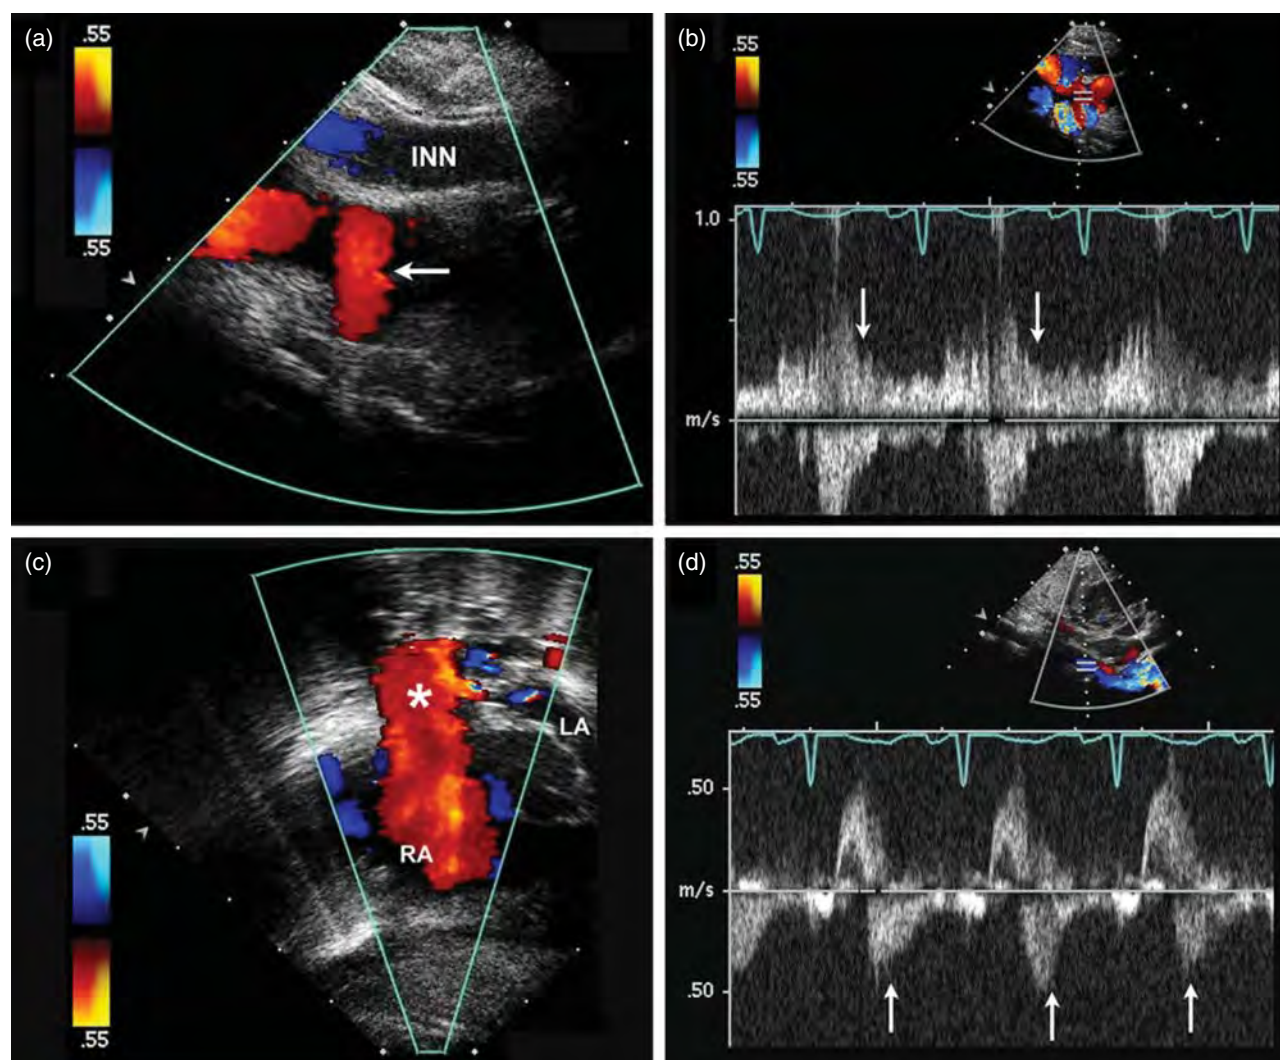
Characteristic echocardiographic findings in neonate with high output cardiac failure resulting from large vein of Galen aneurysmal malformation (VGAM). (a) Suprasternal notch image showing color flow toward the transducer, indicating flow reversal in proximal descending aorta (arrow). A dilated innominate vein (INN) is seen superior to the arch vessels. (b) Pulsed-wave Doppler interrogation of aortic arch vessels from suprasternal notch indicating holodiastolic flow toward the transducer, evidence of high flow into cerebral vessels (arrows). (c) Subcostal coronal imaging demonstrating a very dilated superior vena cava (asterisk) entering the right atrium (RA). The atrial septum is bowed toward the left atrium (LA). (d) Abdominal aorta Doppler shows diastolic flow reversal (arrows) consistent with proximal runoff from the large VGAM.
